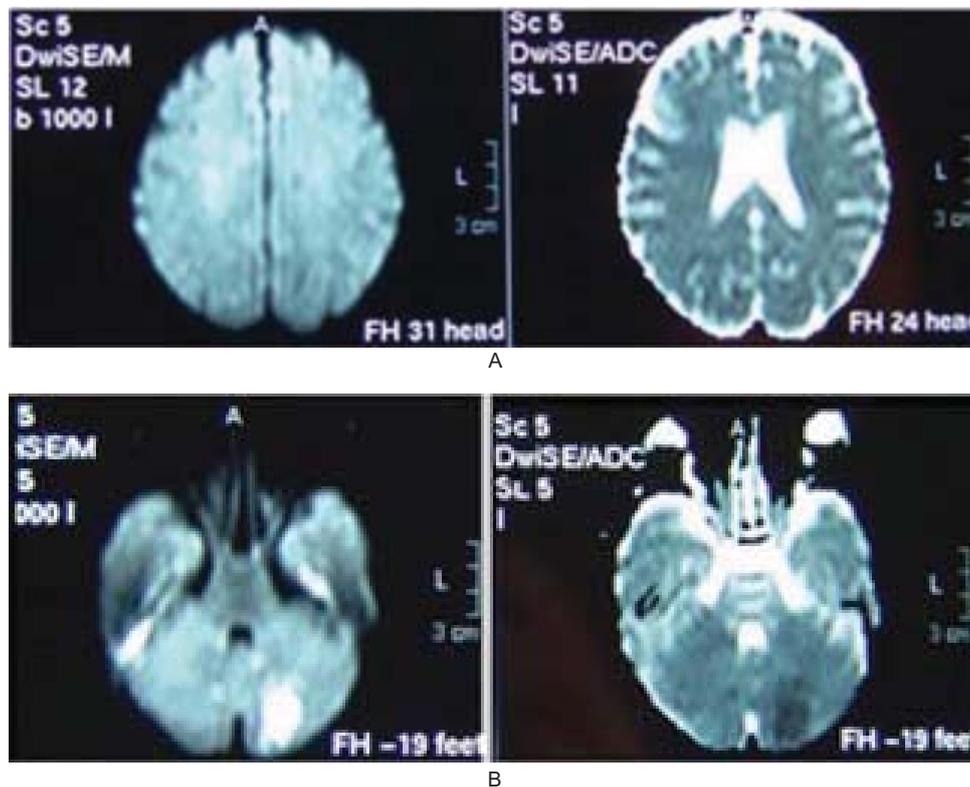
A) Normal DWI (left side) and ADC map (right side). B) DWI images (left side) show a hyperintense area in the left hemisphere of the cerebellum of a patient with isolated vertigo, which has a low ADC value (right side).
